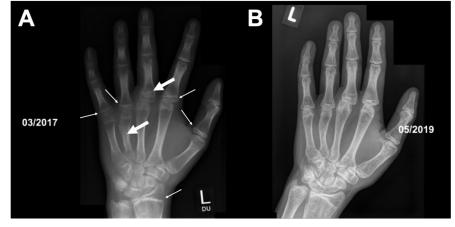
X-ray of a patient with aromatase deficiency: (A) left hand before and (B) after therapy with oestrogen; thick arrows label fractures, thin arrows label some unclosed epiphyseal plates.
